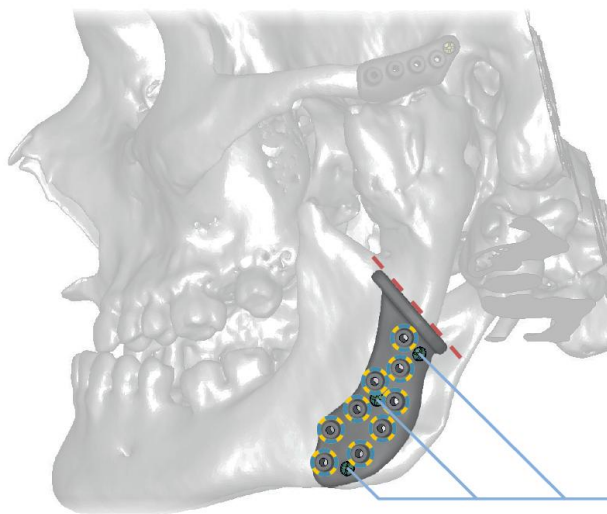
Project of bone resection template placed over a 3D computed tomography reconstruction. A trial template positioned and fixed to the left mandibular ramus with three 2.0 x 6.0 mm screws (indicated by blue lines).
